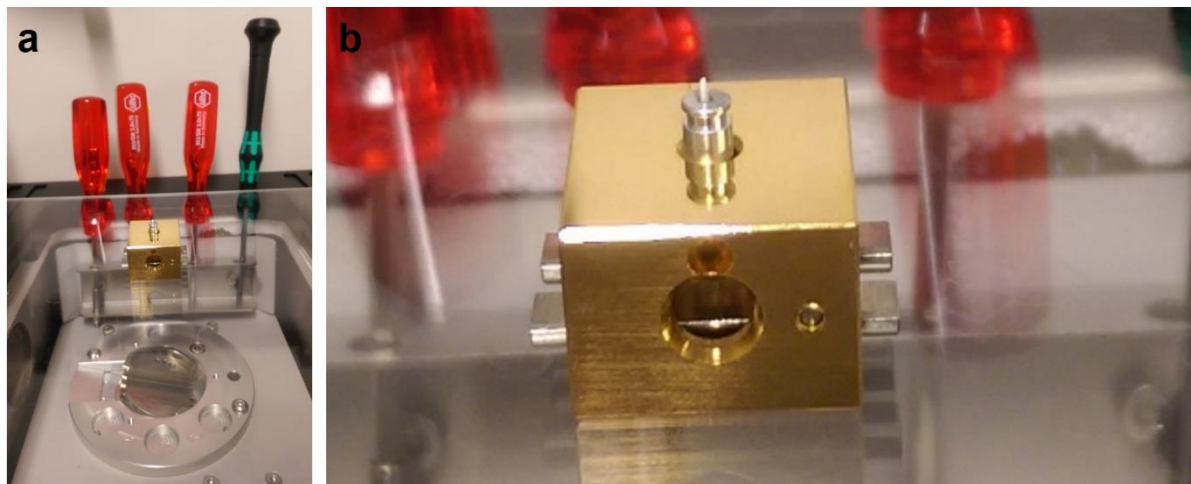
Equipment design for sample scanning using synchrotron-radiation computed tomography. a, Stage containing sample is fixed in place. b, 5 mm samples were cut from dried constructs and were placed in the centre of the stage used for high-resolution scanning.
